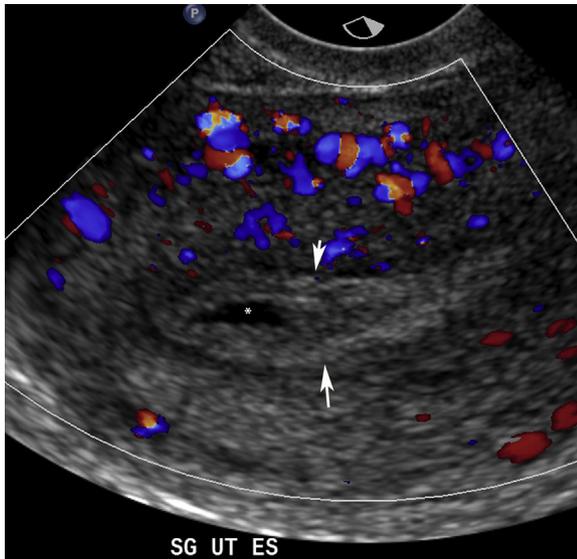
A 22-year-old woman with pelvic pain and fever. She was found to have a tubo-ovarian abscess on computed tomography. Transvaginal pelvic ultrasound demonstrates thickening of the endometrium (arrows) with fluid and debris in the endometrial cavity (asterisk) in keeping with endometritis. Tests were positive for *Chlamydia trachomatis* and she was treated with antibiotics. In some cases of endometritis, there is gas in the endometrial cavity characterized by dirty shadowing. This figure is available in colour online at <http://carjonline.org/>.
